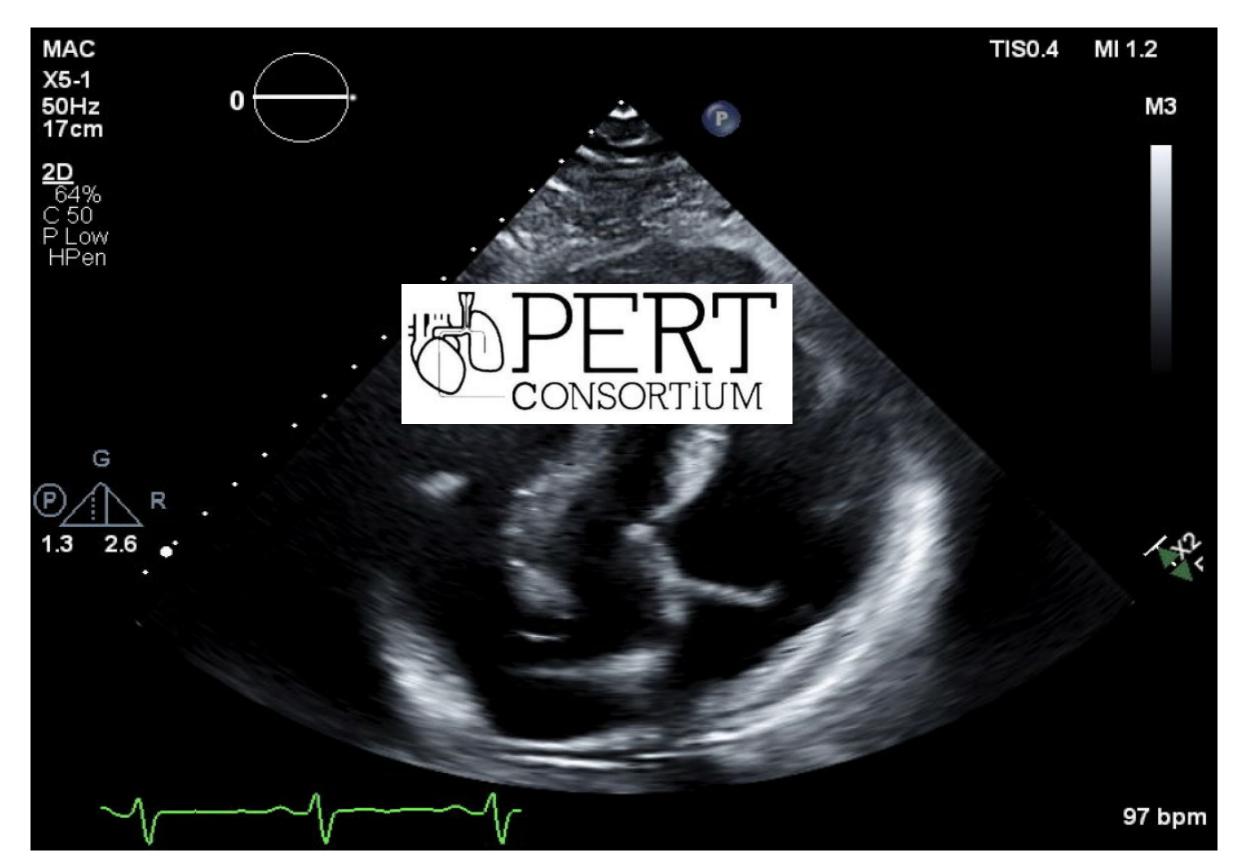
Apical four-chamber view echocardiogram showing mobile mass within right ventricle
